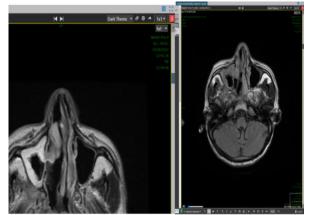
(a)T2 and; (b) FLAIR images showing Bilateral maxillary sinusitis (right>left) showing hyperintensity and mucosal thickening.
